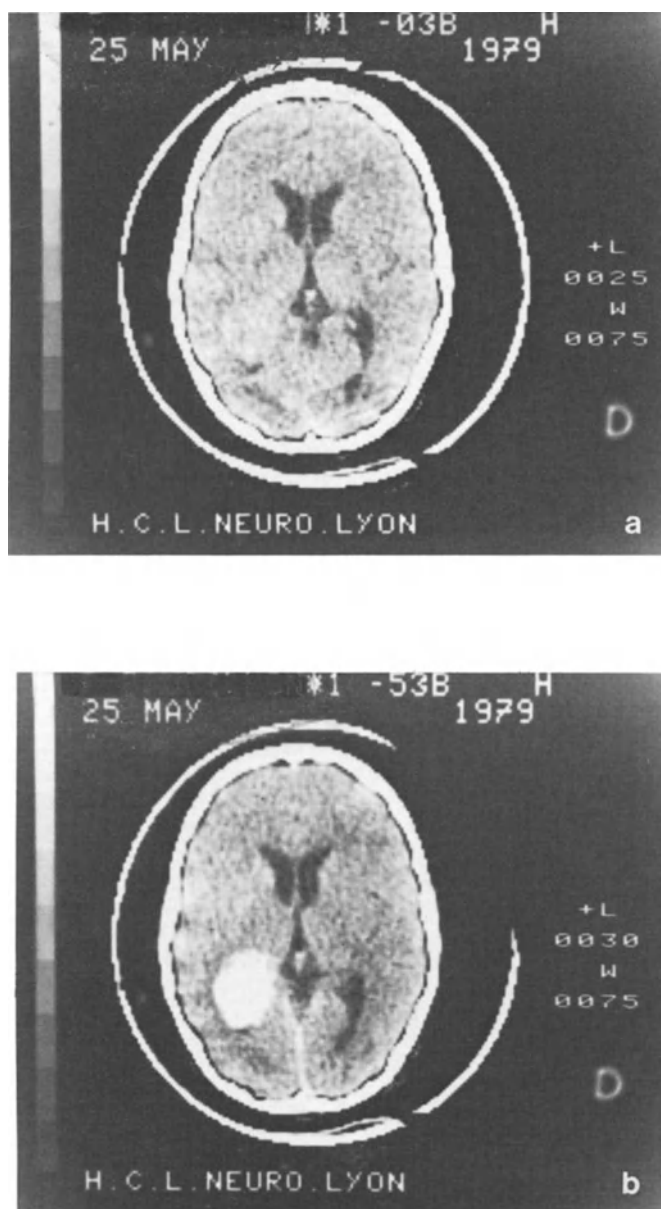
Left atrial choroid plexus papilloma. a) Pre-contrast CT: isodense mass.
